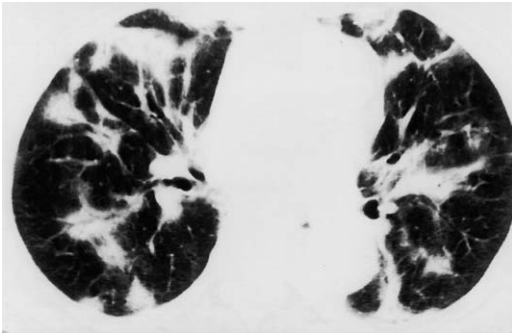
Nodular appearance of BOOP in a 72-year-old woman on nitrofurantoin. HRCT findings include bilateral patchy areas of consolidation, many of which appear nodular. Distribution is primarily peripheral with some in a peribronchovascular distribution.
